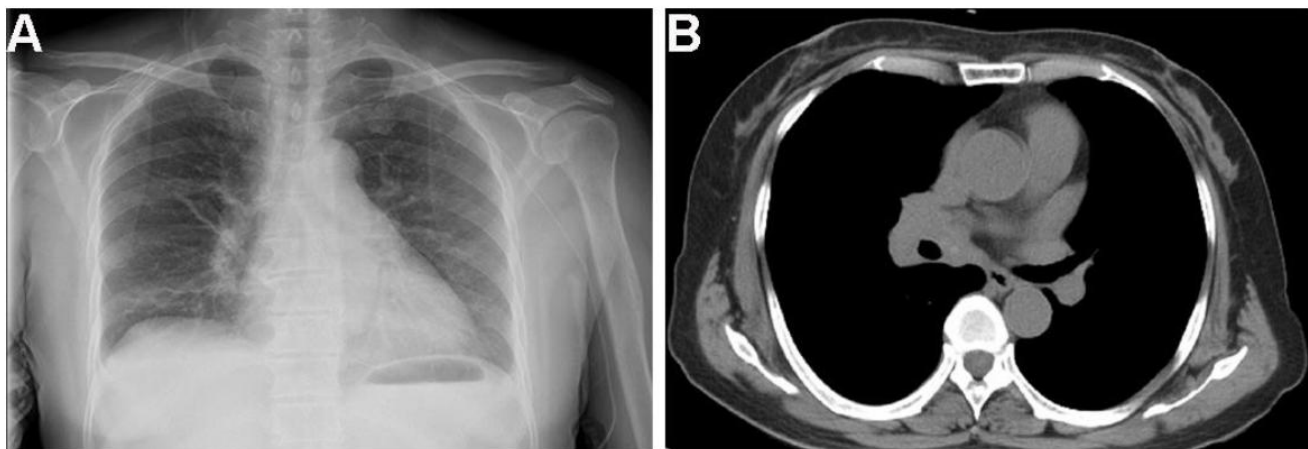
Chest X-ray implied the right side of the hilar enlargement (A); Chest high-resolution CT: right middle lobe mass and lymph nodes swelling (B).
